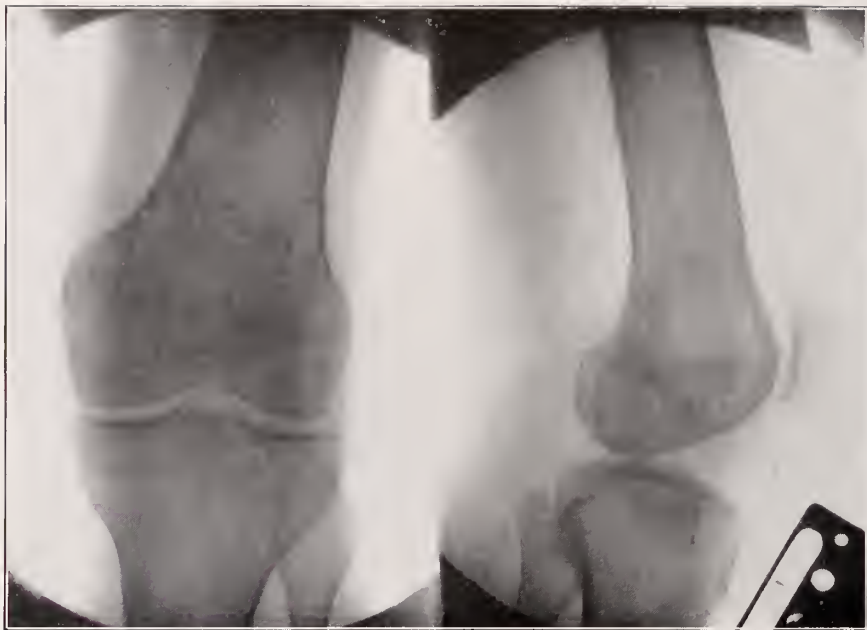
Path. No. 23881. X-Ray of Bone Changes in Traumatic Arthritis. See page 154.
